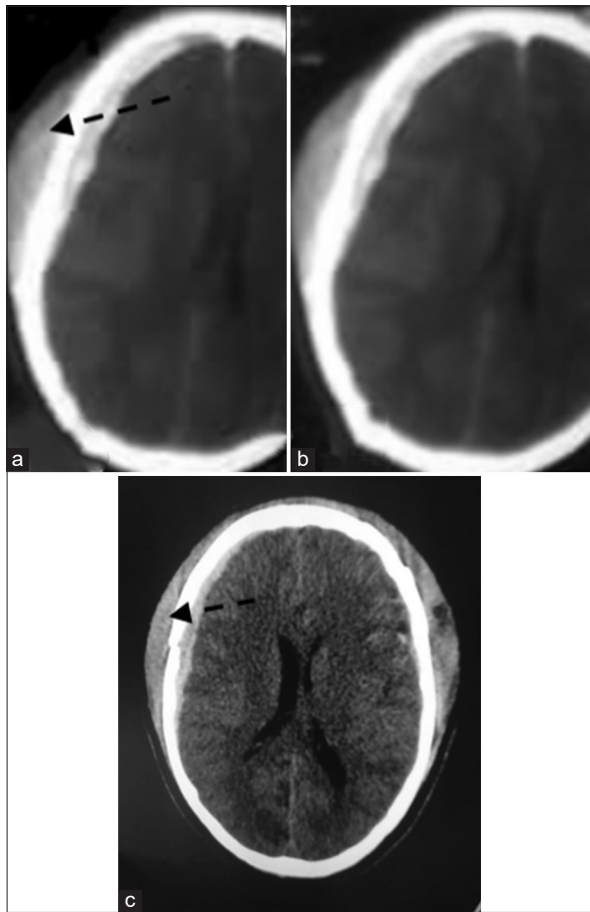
(a and b) (1 h after trauma) computed tomography scan showing thick right acute subdural hematoma, 12 mm of midline shift with subgaleal hematoma (marked with broken arrow). (c) (5 h after trauma) computed tomography scan showing significant reduction of acute subdural hematoma and midline shift with enlargement of subgaleal hematoma (marked with broken arrow)
